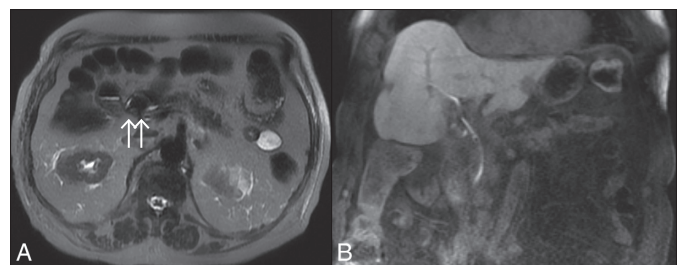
(A) Magnetic resonance imaging demonstrating the resolution of the mass-like density in the duodenum (arrows) and (B) the presence of choledocholithiasis along with the cholecystoenteric fistula.
